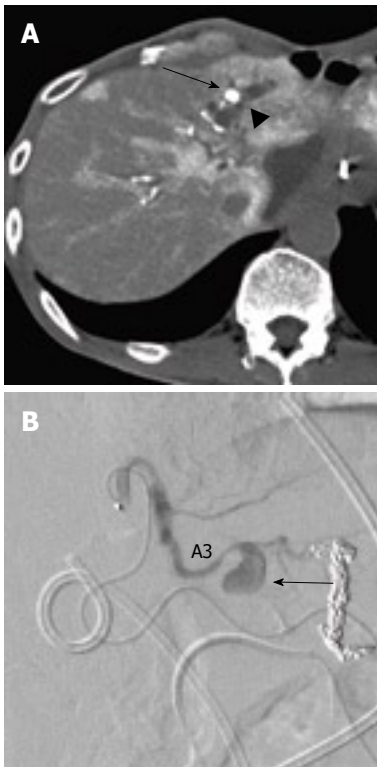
CT and Angiography image of an 84-year-old man with haemobilia. A: CT revealing a high-density area which was 1 cm in diameter at the lateral segment in the artery phase (arrows). It protruded into the intrahepatic duct (arrowhead). B: Angiography showing a small aneurysm over the A3, which was the second branch of the left hepatic artery (arrows).
